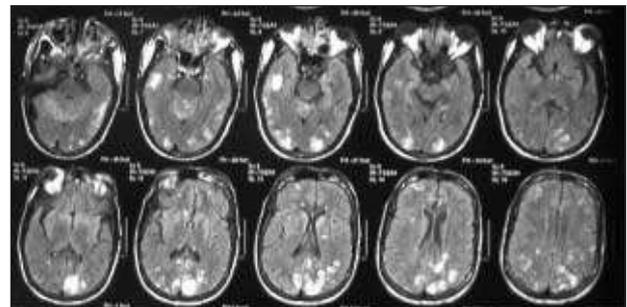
Cerebral Magnetic Resonance Imaging features: subcortical areas with hypersignal in FLAIR and hyposignal in T1, predominantly in the temporal and parieto-occipital lobes, suggesting edema. Brain cortex is relatively spared.
